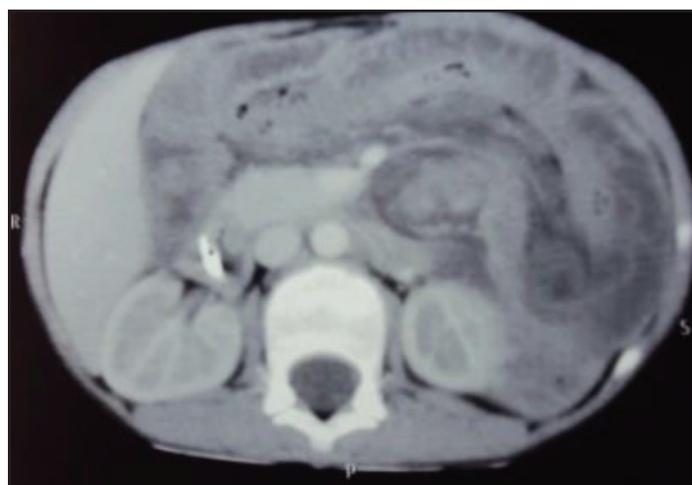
CT Abdomen showing jejun-jejunal intussusception (case 1).
